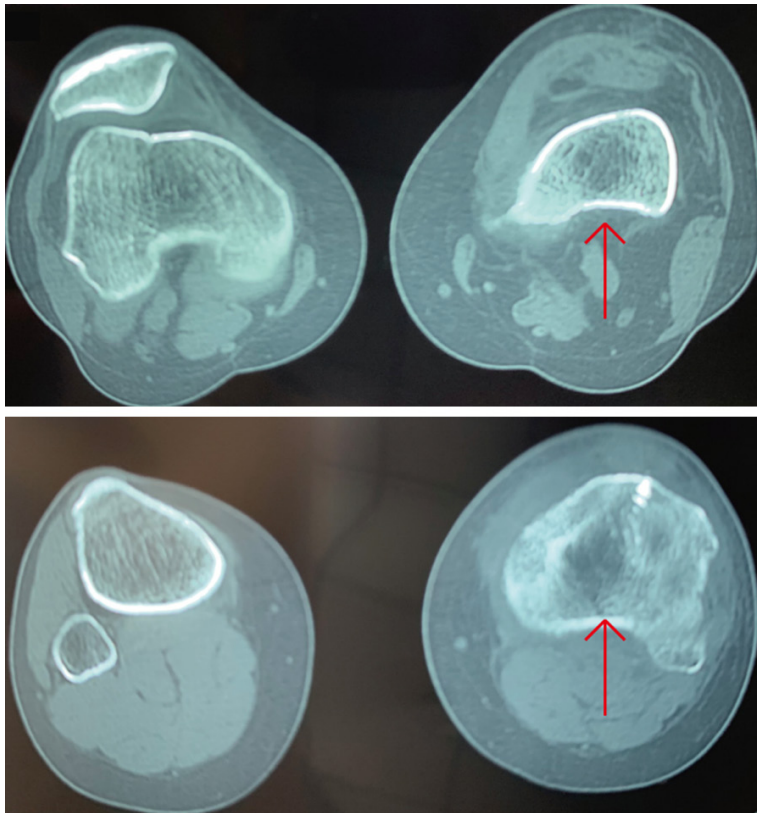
CT scan indicated no visualization of the left patella and uneven density of the left upper tibia and left medial femoral condyle.
